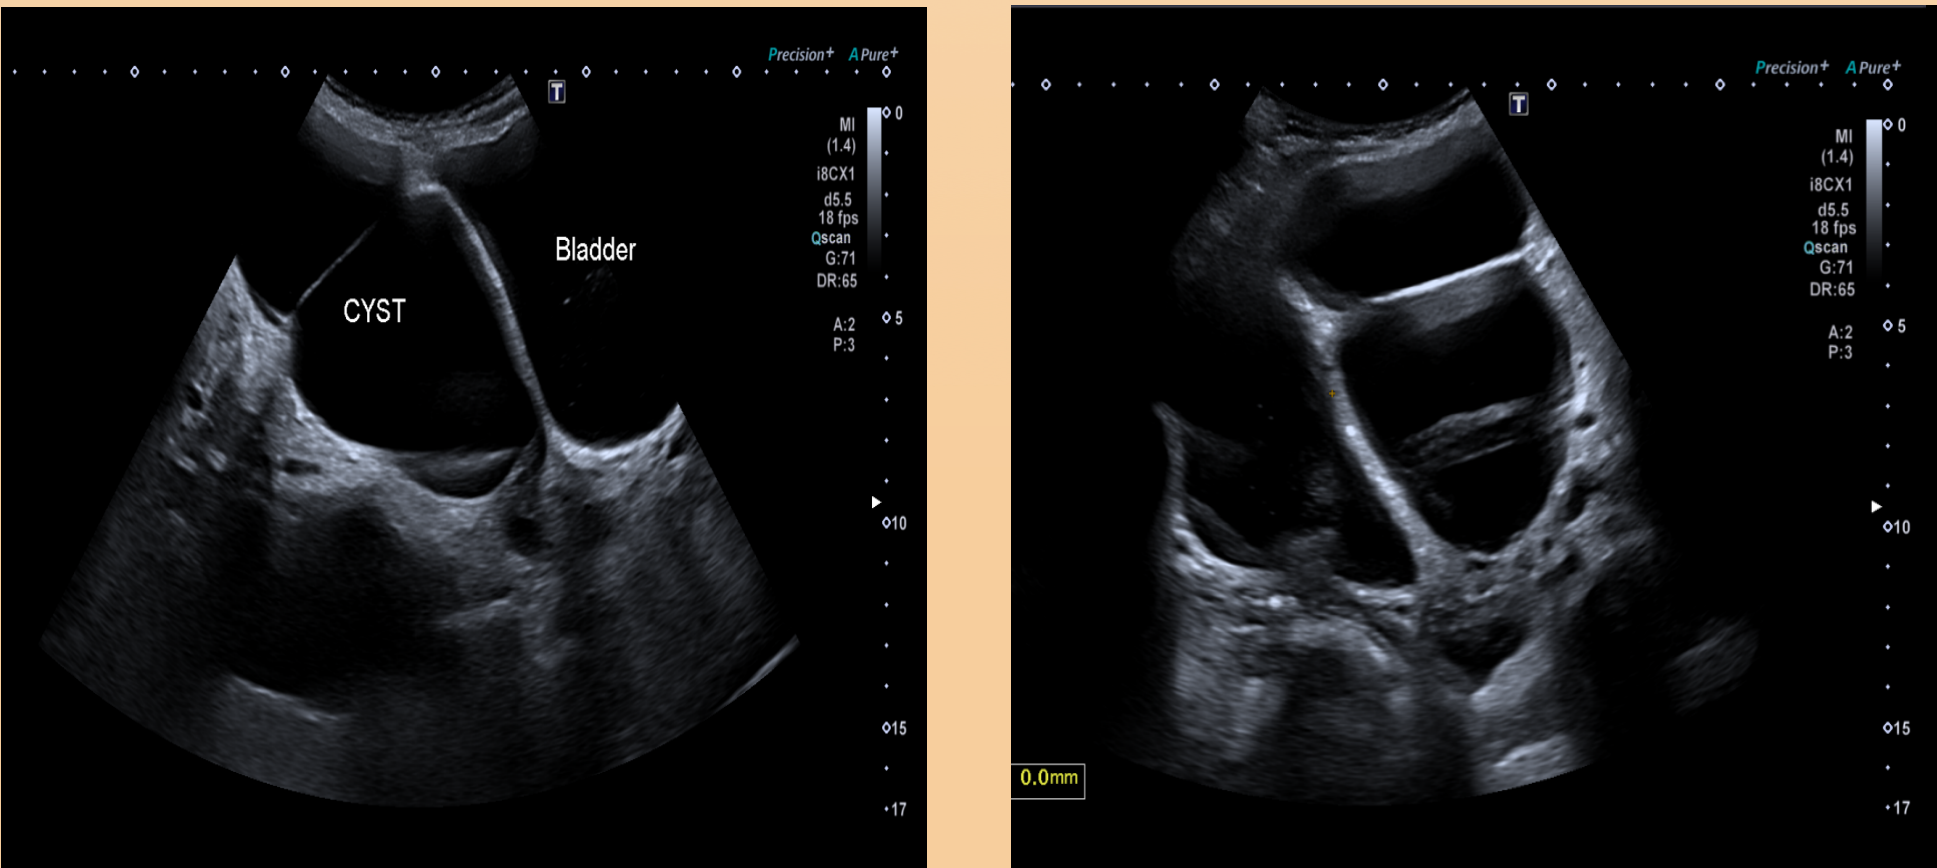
Ultrasound pre-conception showing a large left adnexal complex mass.
